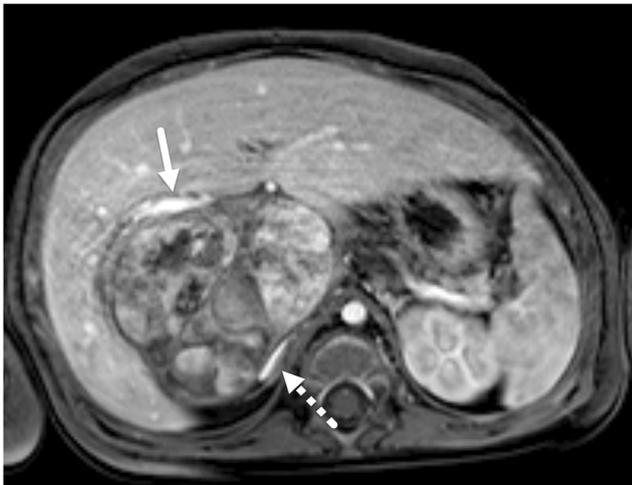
Caudate involvement. Axial T1-weighted MR image obtained in the portal venous phase of imaging after administration of a hepatocyte-specific contrast agent in a child with hepatoblastoma shows a tumor arising from the caudate. The tumor is situated between the portal vein (arrow) and the inferior vena cava (dashed arrow). This tumor would be classified as PRETEXT II. Even though the inferior vena cava and portal vein are compressed, the tumor is considered V-negative and P-negative because the lumen is not obliterated and the tumor does not encase the vessel more than 180°
